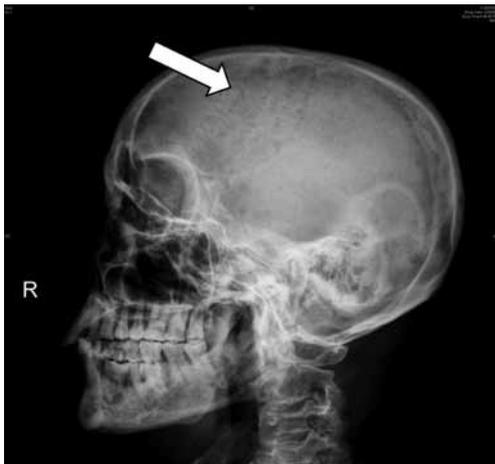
Skull x-ray showed multiple lytic lesions.
